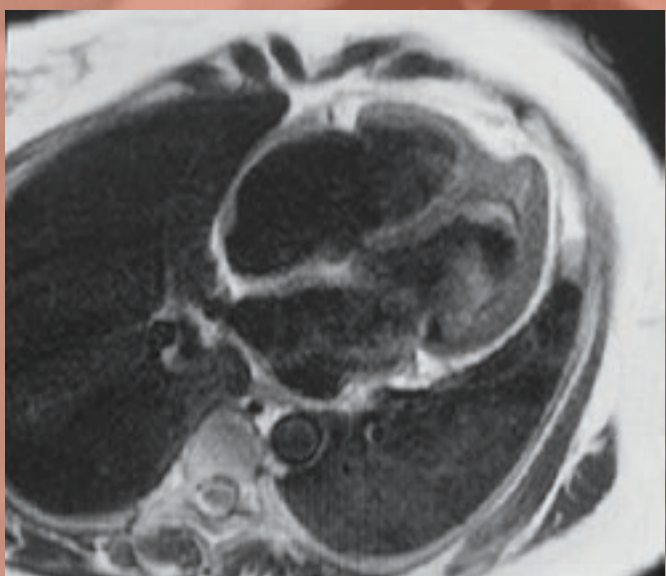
Cardiac MRI demonstrating complications from heart involvement in EGPA (Churg-Strauss). This patient has endomyocardial fibrosis at the left ventricular apex with a large apical thrombus. Image and caption reprinted with permission from Elsevier.
